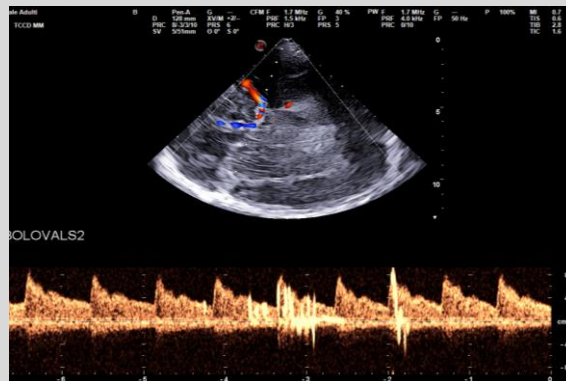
Transcranial Doppler bubble study
